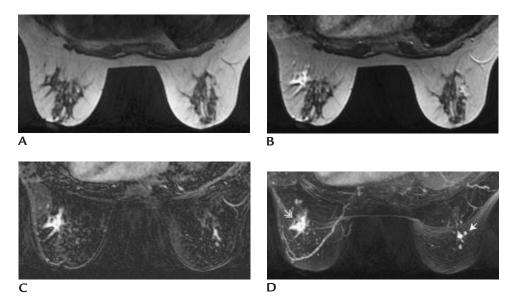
Evaluation of patient with newly diagnosed invasive lobular carcinoma in the left breast. (A) T1-weighted, axial image pre-contrast. (B) T1-weighted image immediately following the contrast bolus; same slice as that shown in A. (C) Subtraction image at same slice as shown in A and B. (D) Maximum intensity projection. Irregular spiculated mass (*double headed arrow*) corresponding to the site of the patients known malignancy in the left breast. Multiple enhancing masses (multifocal) are present in the right breast (*arrow*). These could not be identified on ultrasound. MR guided biopsy yielded lobular carcinoma in situ. Four separate sites (largest measuring 1 cm) of invasive lobular carcinoma and extensive lobular carcinoma in situ are identified at the time of the lumpectomy on the right.
